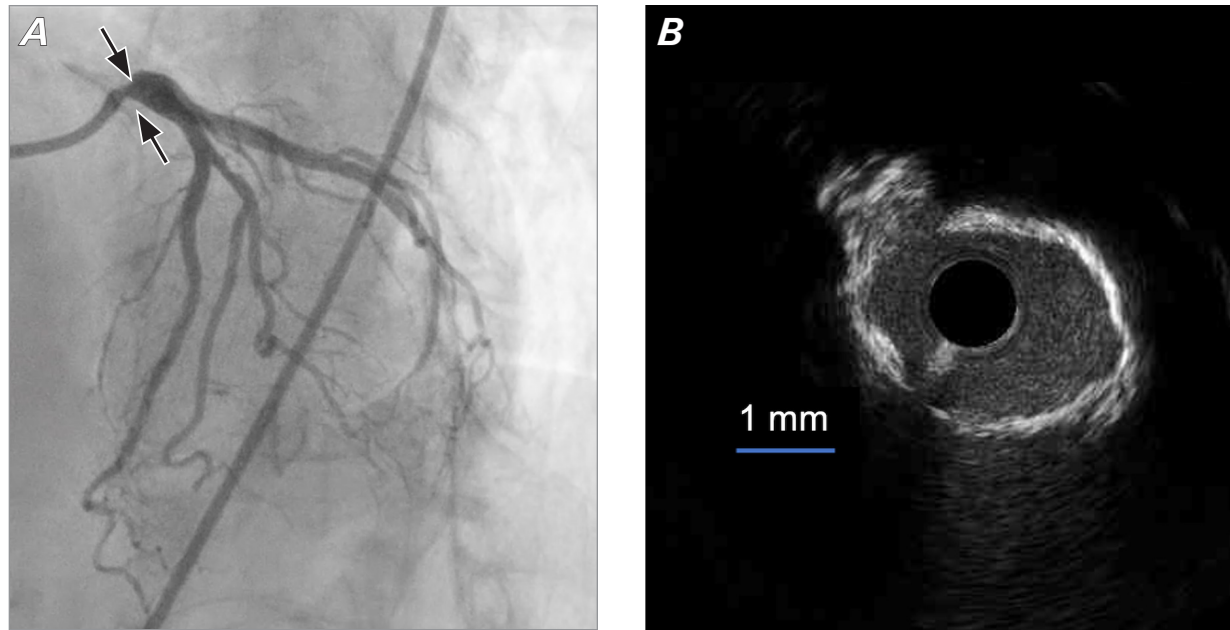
Follow-up angiogram of the coronary artery and intravascular ultrasound. A) Follow-up angiogram shows no restenosis in the LMT ostium (arrows). The supplemental motion image also shows the follow-up angiography of the lesion. B) Follow-up intravascular ultrasound at the LMT ostium shows a minimal lumen area of 4.69 mm².
